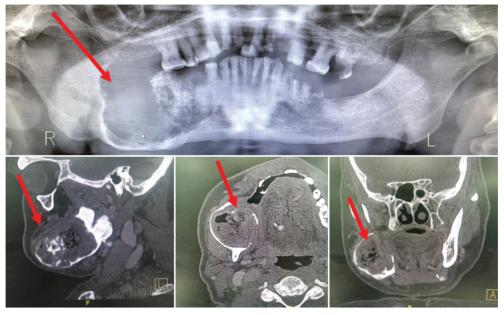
Pre-operative panoramic and CT scan of the Ameloblastoma Tumor at different section.
